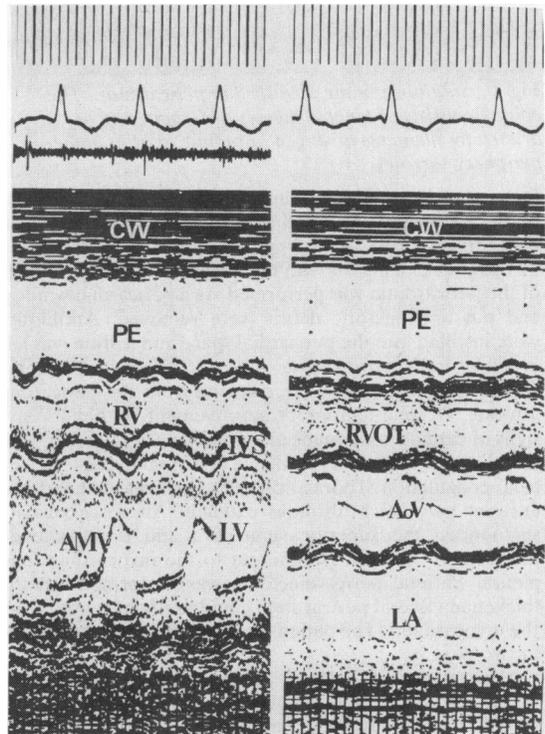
Echocardiogram showing a large anterior pericardial effusion (PE). CW—chest wall; RV—right ventricle; RVOT—right ventricular outflow tract; IVS—interventricular septum; AMV—anterior mitral valve leaflet; AoV—aortic valve; LA, LV—left atrium and ventricle.
